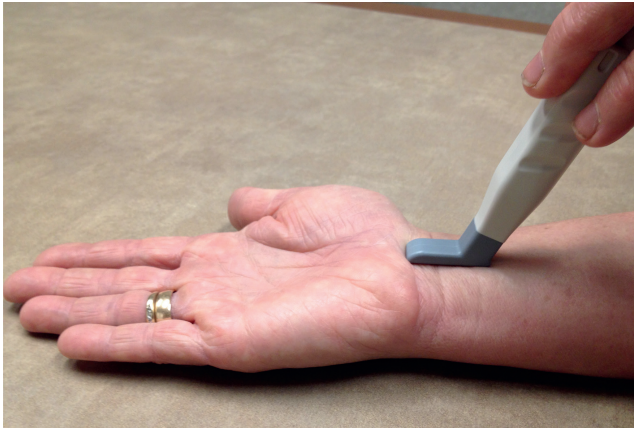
Placement of the probe on the wrist when making ultrasound scans of the median nerve and flexor tendons of the middle finger at the carpal tunnel.
